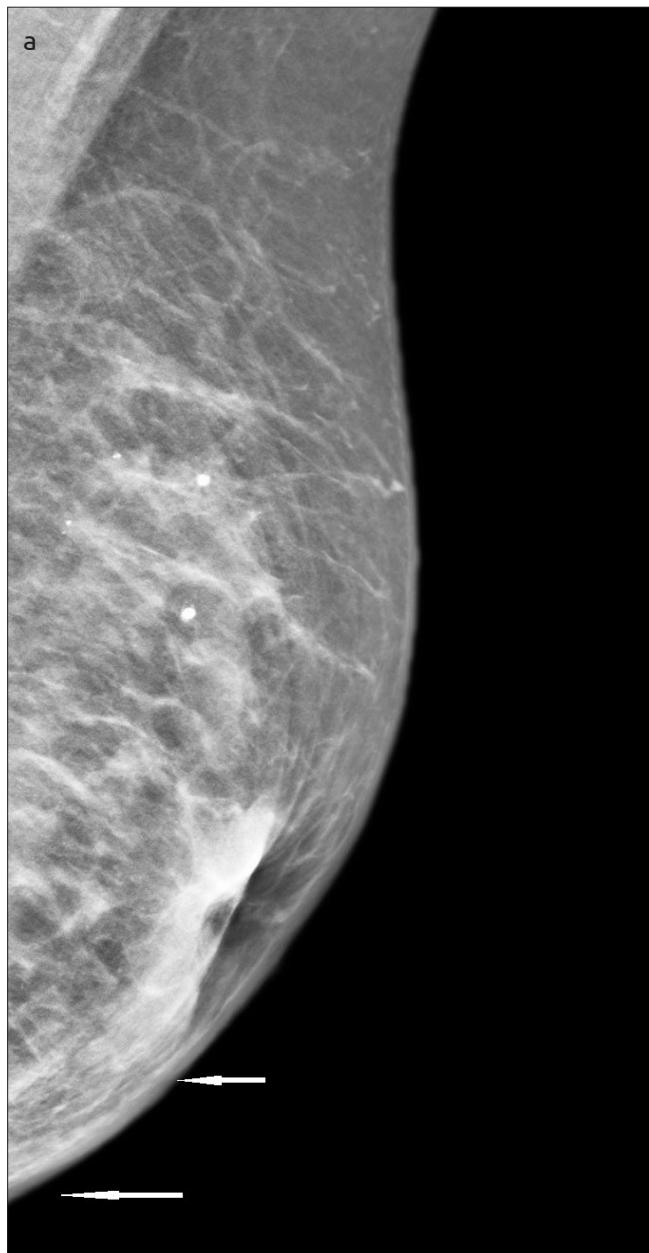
a, b. (a) Mammography (left mediolateral oblique view) demonstrates trabecular thickening and skin thickening (arrows) in the lower outer quadrant of the left breast. Retraction of both nipples are noted as incidental findings. (b) Ultrasound of the left breast: irregular, vertically oriented, non-mass lesions (arrows) are seen
